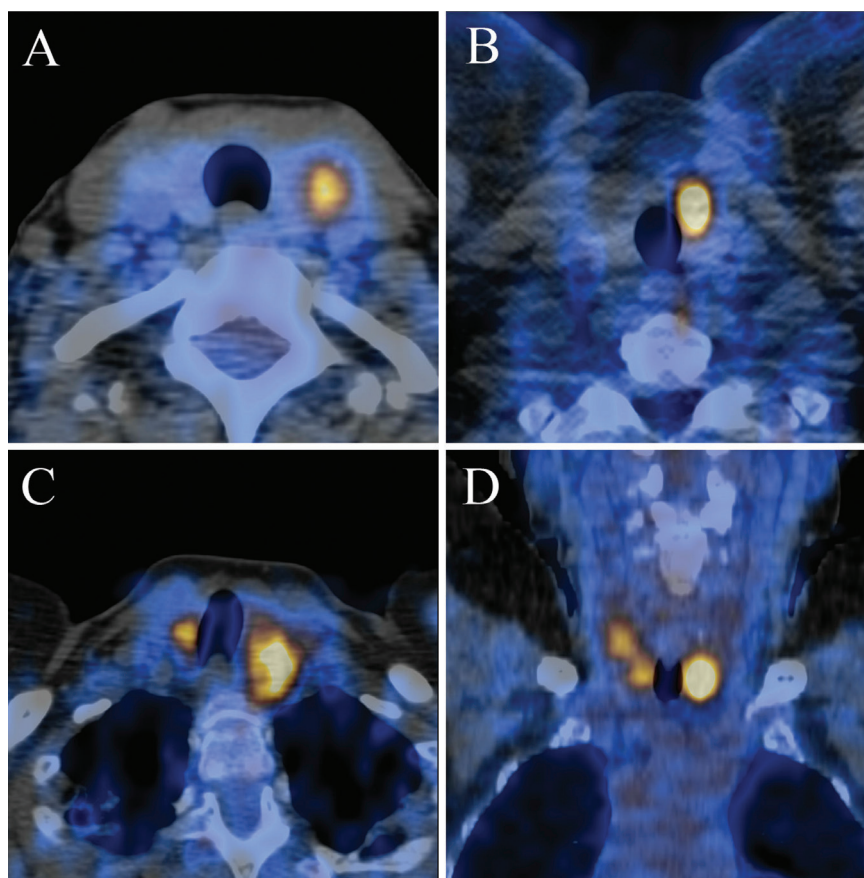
Four cases of incidental focal ^{18}F -FDG uptake in the thyroid. Transaxial PET/CT fusion image of a benign left thyroid incidentaloma in a 52-year-old woman with a prior history of cervical cancer, with SUV_{max} 4.4, biopsied to reveal a benign follicular lesion (A), transaxial PET/CT fusion image of a malignant left thyroid incidentaloma in a 40-year-old man with a prior history of melanoma, with SUV_{max} 11.8, biopsied to reveal a papillary carcinoma follicular variant (B). Transaxial PET/CT fusion image of a bilateral focal benign thyroid incidentaloma in a 65-year-old woman with a prior history of lymphoma, with SUV_{max} 7.8 of left lesion and SUV_{max} 6.4 of right lesion, biopsied to reveal benign nodular hyperplasia (C), coronal PET/CT fusion image of a bilateral malignant thyroid incidentaloma in a 70-year-old woman with a prior history of colorectal carcinoma, with SUV_{max} 8.1 in the left lesion and SUV_{max} 4.5 in the right lesion, biopsied to reveal a multifocal papillary carcinoma, classical variant on a background of Hashimoto's thyroiditis (D)
